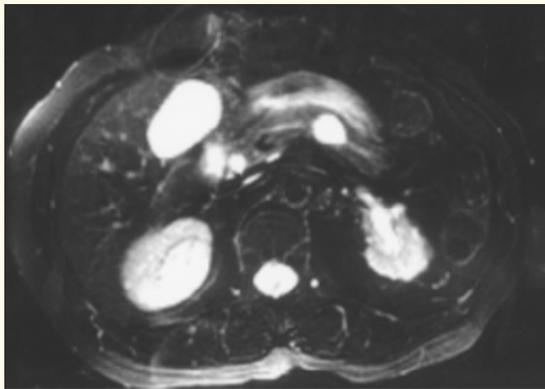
MRI image of a cystic lesion of the pancreatic body that is suspected of communicating with the pancreatic canal.
